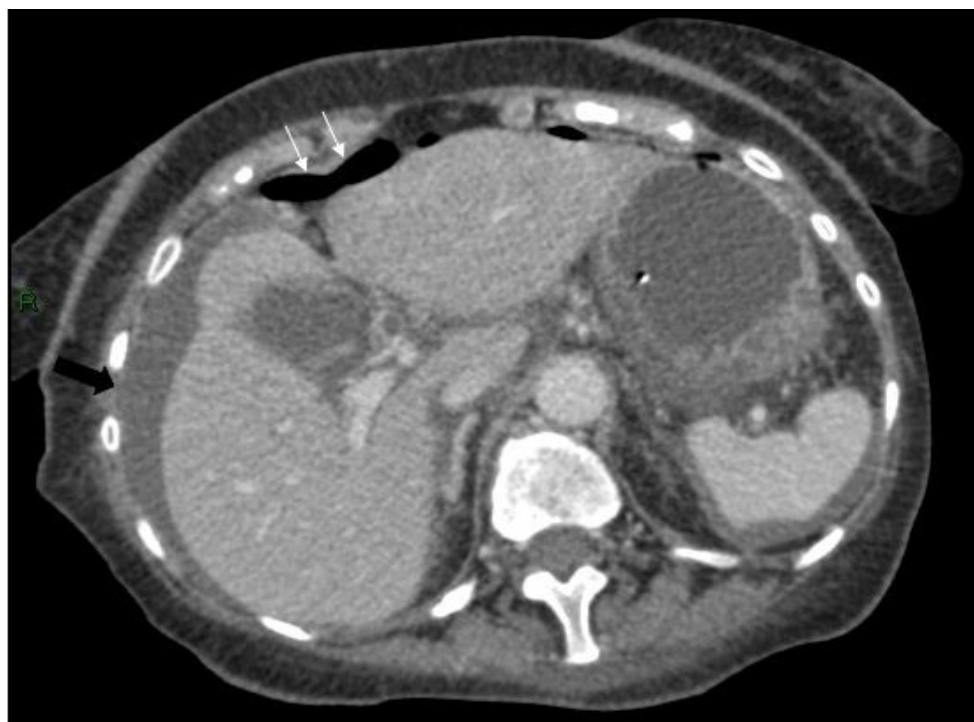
Axial CT scan of abdomen showing free air anterior to the liver (white arrows) and free fluid around the liver and spleen (black arrows).
